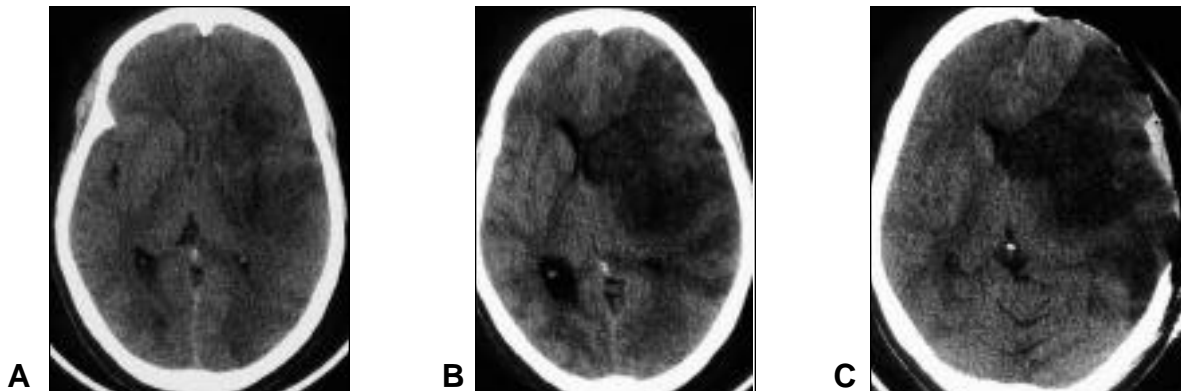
A 44-year-old female with a history of systemic lupus erythematosus. She developed mild aphasia but arrived at hospital too late for thrombolytic therapy. On day one in hospital she had two focal seizures and subsequently remained drowsy. On day 2, she worsened clinically, with global aphasia and right hemiplegia. The day 2 CT scan (A) revealed complete MCA and PCA infarction with 7 mm anterosseptal shift.
